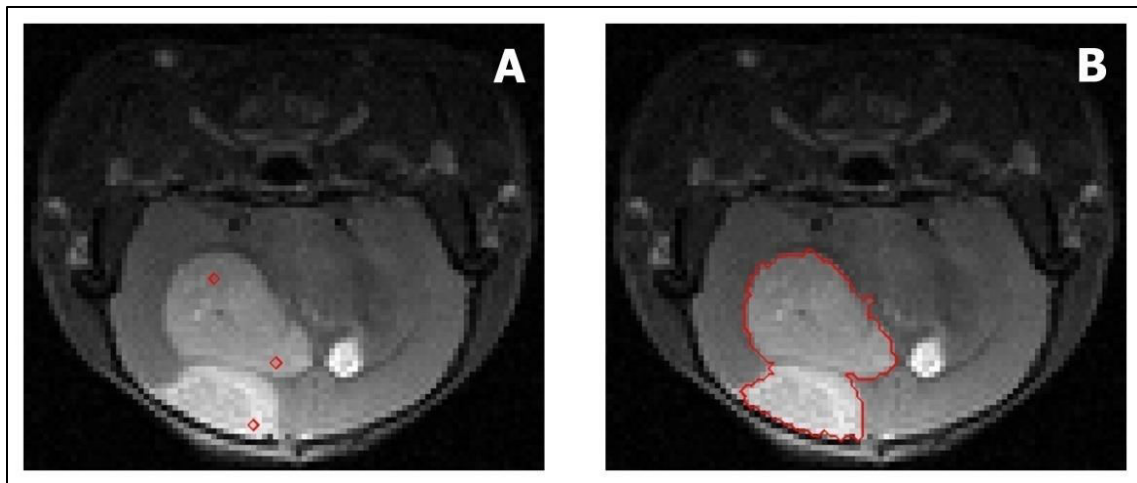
Region growing algorithm implementation for the segmentation of tumor on a T₂-weighted MR image. (A) Figure showing the initial seeds (*red dots*). (B) Figure showing the final segmented tumor image. Threshold was set to a value of $0.11 \times (\text{region mean})$.
